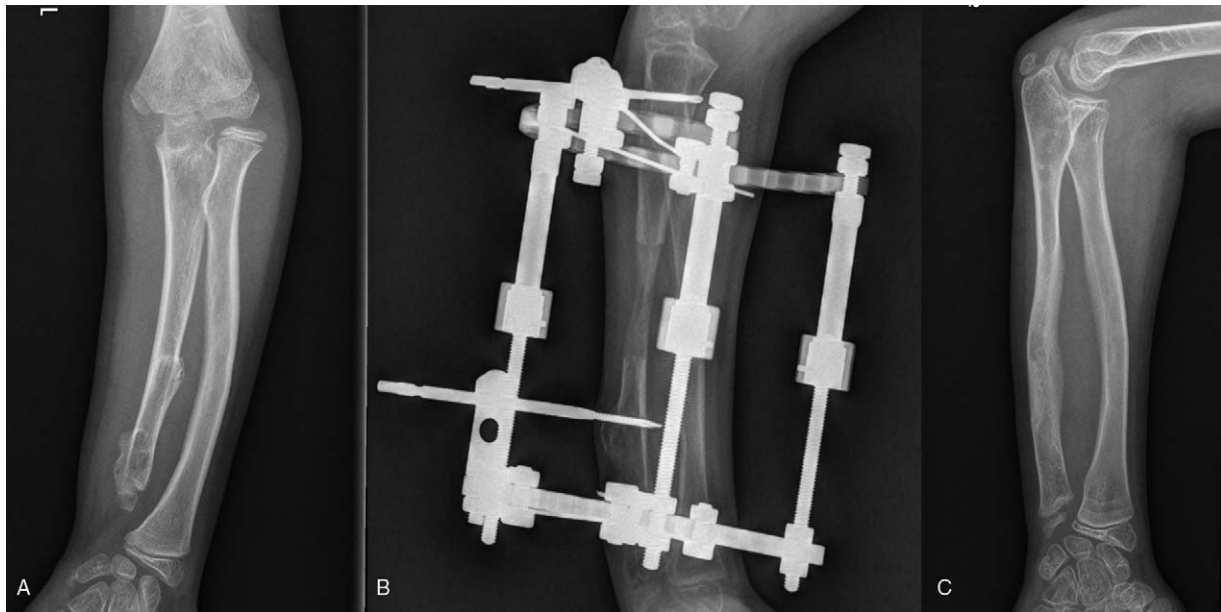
(a, b) The ulnar was gradual lengthened using a circular external frame, show a significant shorter bone healing index in this study, 3.8 cm were gained and the HI for this 10-year-old boy is 40.7 days/cm. (c) Radiograph of the forearm 14 months after external fixator removed, good relationship between the forearm bones and good remodelling of regenerate bone. HI=healing index
